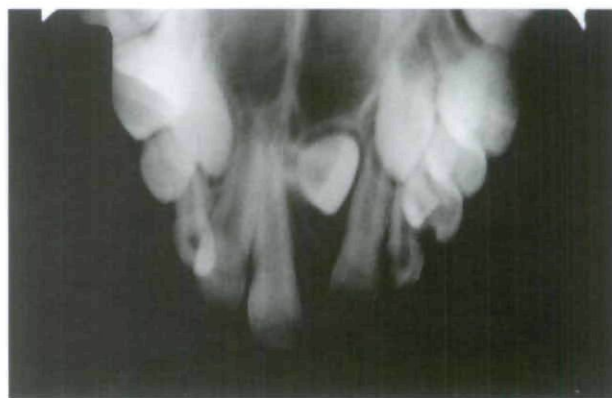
Occlusal radiograph of the affected area.
